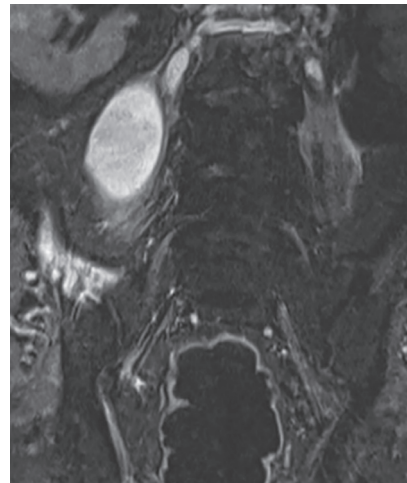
MRI STIR image showing Right psoas showing thick walled lesion
